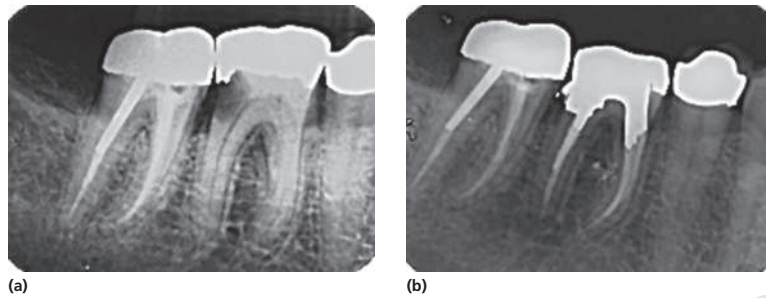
(a) Radiograph of a lower left first molar with little or any coronal structure remaining in a 67-year-old male patient. The patient's dentist suggest the tooth's removal and placement of a crown-restored implant. Note the thinness of the root canal systems, probably due to tertiary dentin formation. (b) Radiograph of the same tooth after endodontic therapy and placement of a crown. Courtesy of Dr. Franklin Tay, Medical College of Georgia.
